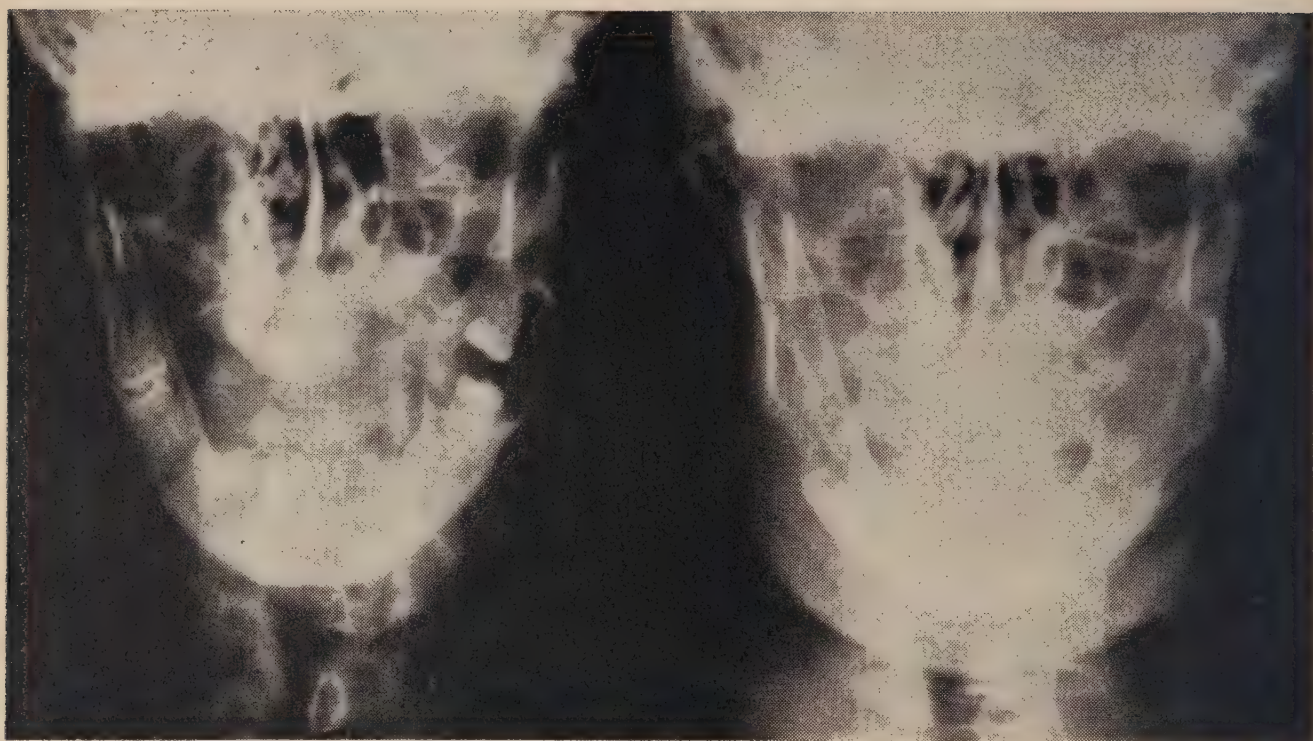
Postoperative radiography.
